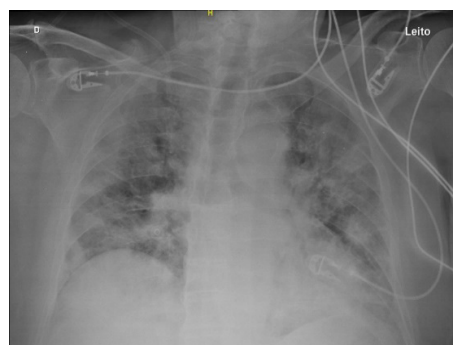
Radiographic evolution of the patient Case 1. A – Admission to the ICU, B – 1st day of hospitalization. ICU: Intensive Care Unit.
